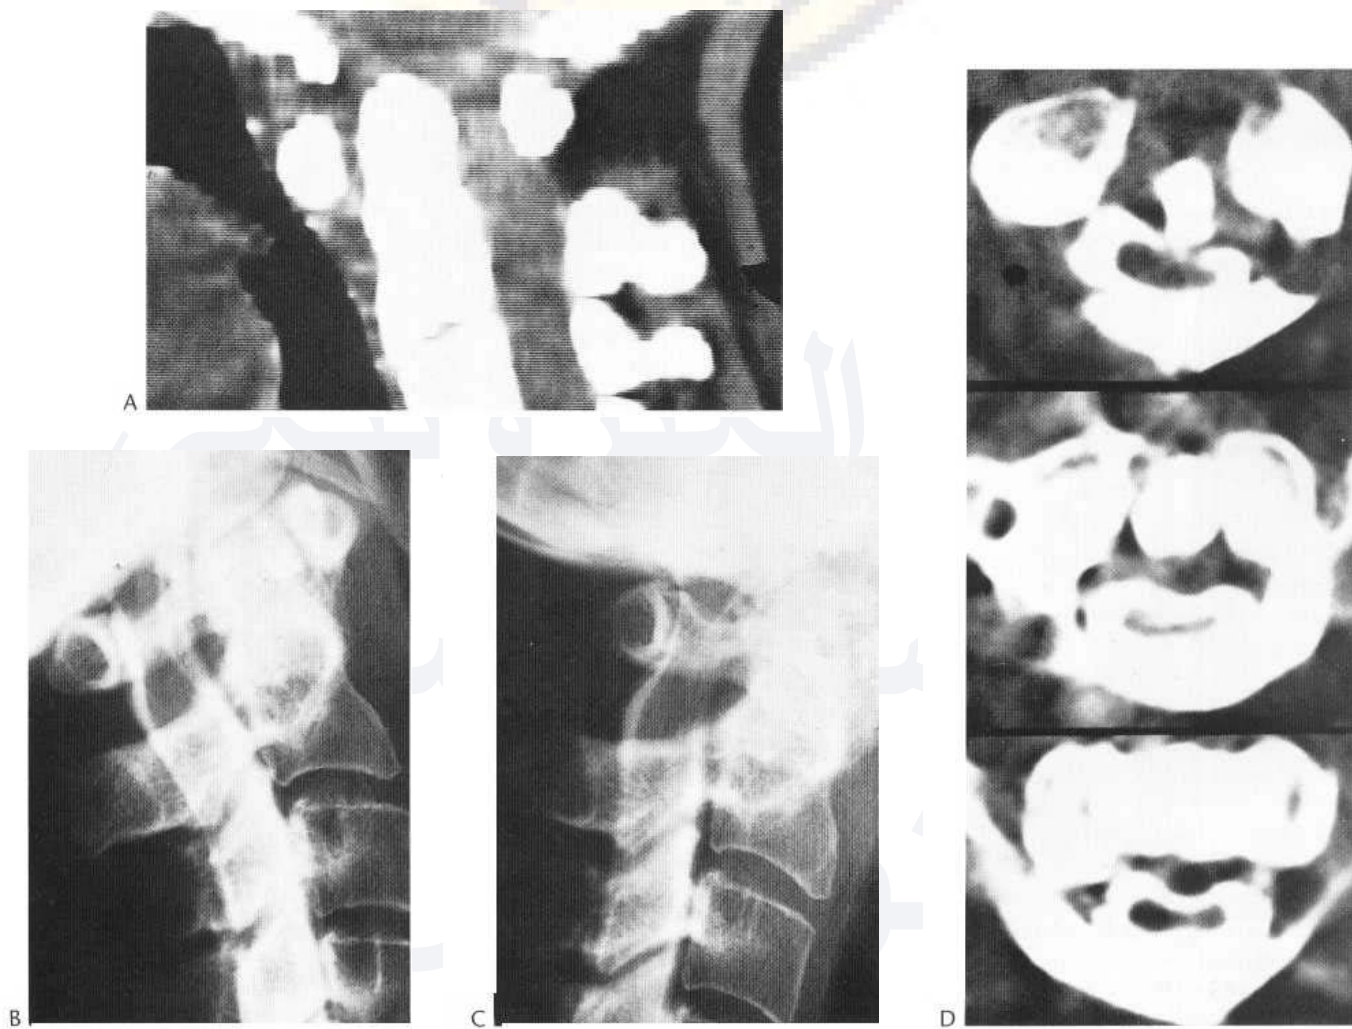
Myelogram and CT myelography in a patient with rheumatoid arthritis and seemingly mild anterior atlanto-axial subluxation and severe spinal cord damage. (A) Sagittal image reformatted from multiple axial slices (no contrast). (B and C) Lateral views of the myelogram in flexion and extension. (D) Axial CT images of the myelogram showing the flattened damaged spinal cord.
